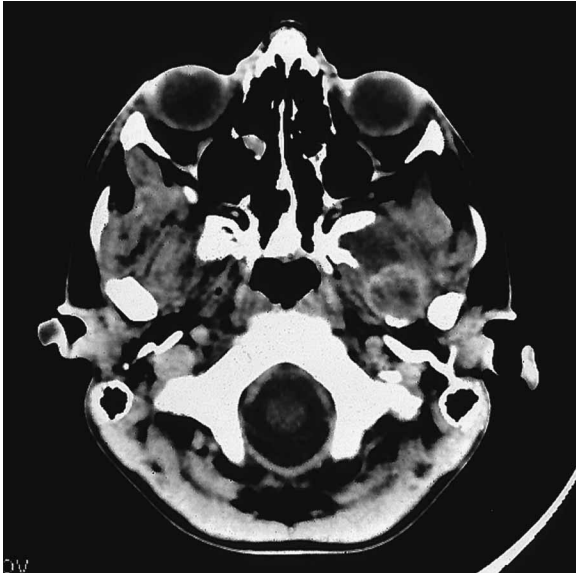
CT scan showing a sarcoma of the skull base in the 6-year-old boy in case 1.
